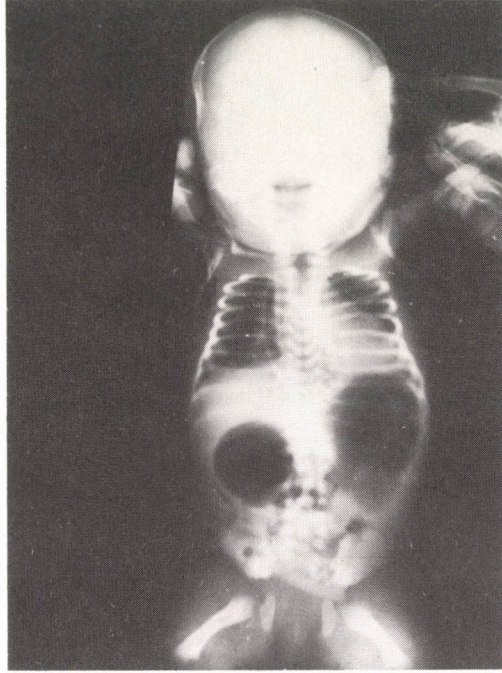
Plain erect X-ray film demonstrates double-bubble sign of duodenal obstruction
